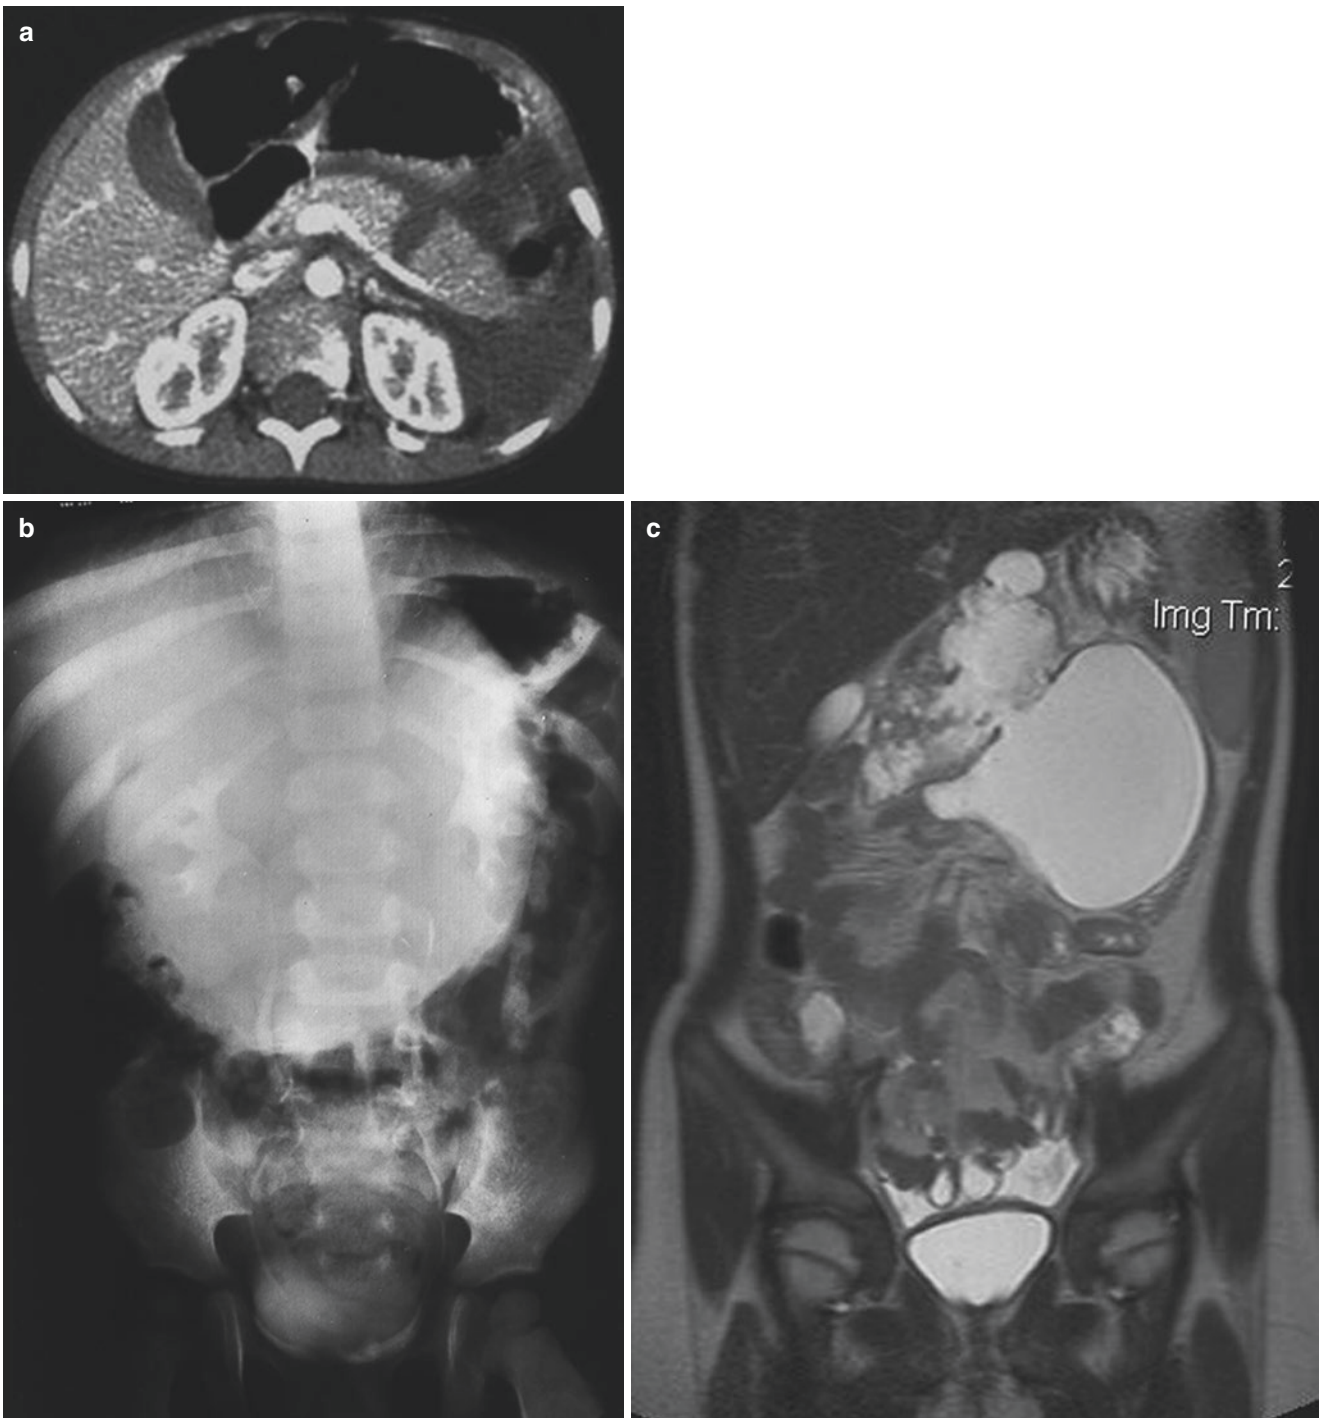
(a) CT scan showing a hemoperitoneum and a fracture of the body of the pancreas. (b) Pancreatic pseudocyst is seen as a soft tissue mass with the transverse colon spread around it and pushed downwards. (c) MRI showing a pancreatic pseudocyst
